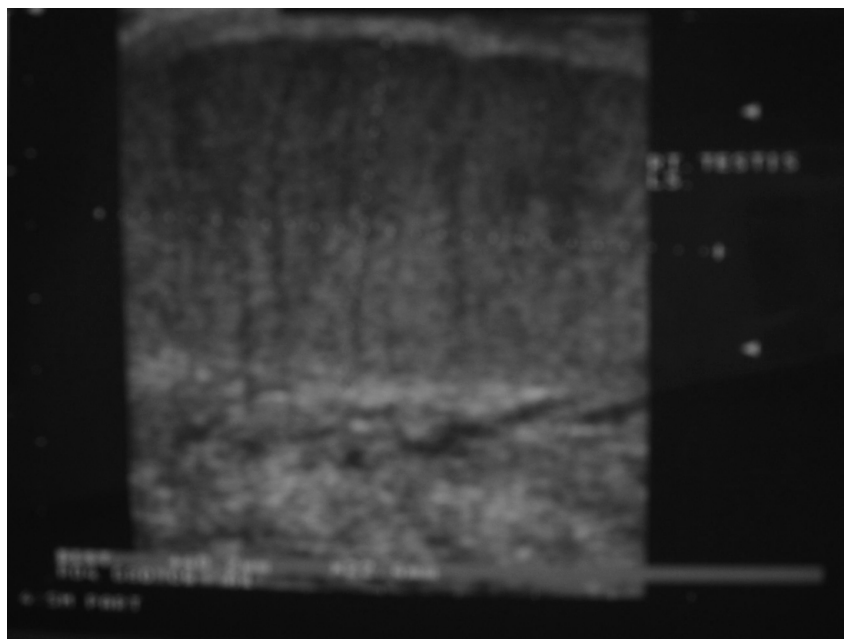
Ultrasound scan of the scrotum showed a swollen and oedematous right testis and epididymis
